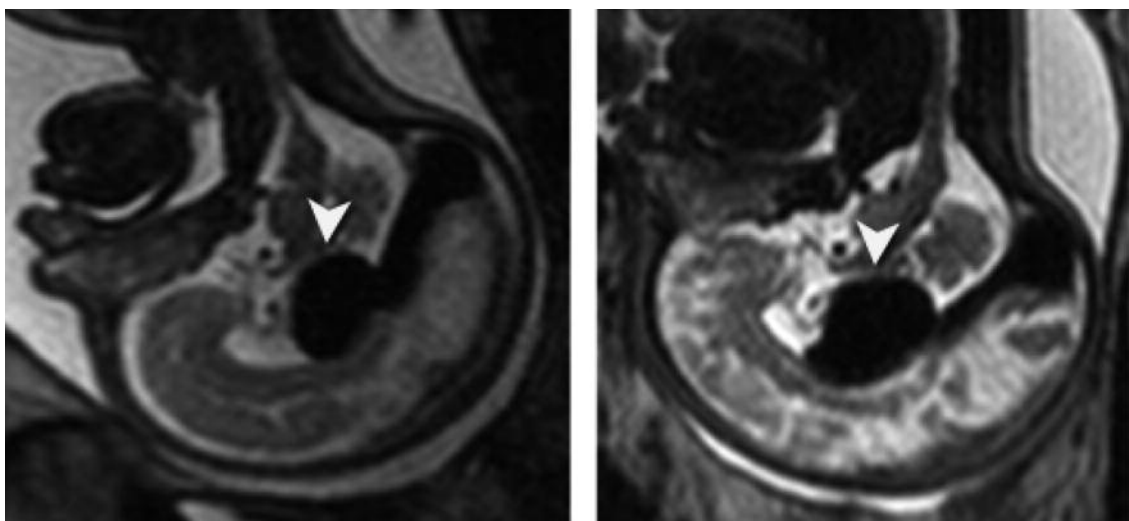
MRI midsagittal view at gestational age 31 weeks (left) and 36 weeks (right) of an aneurism of the Galen vein (arrow head).
